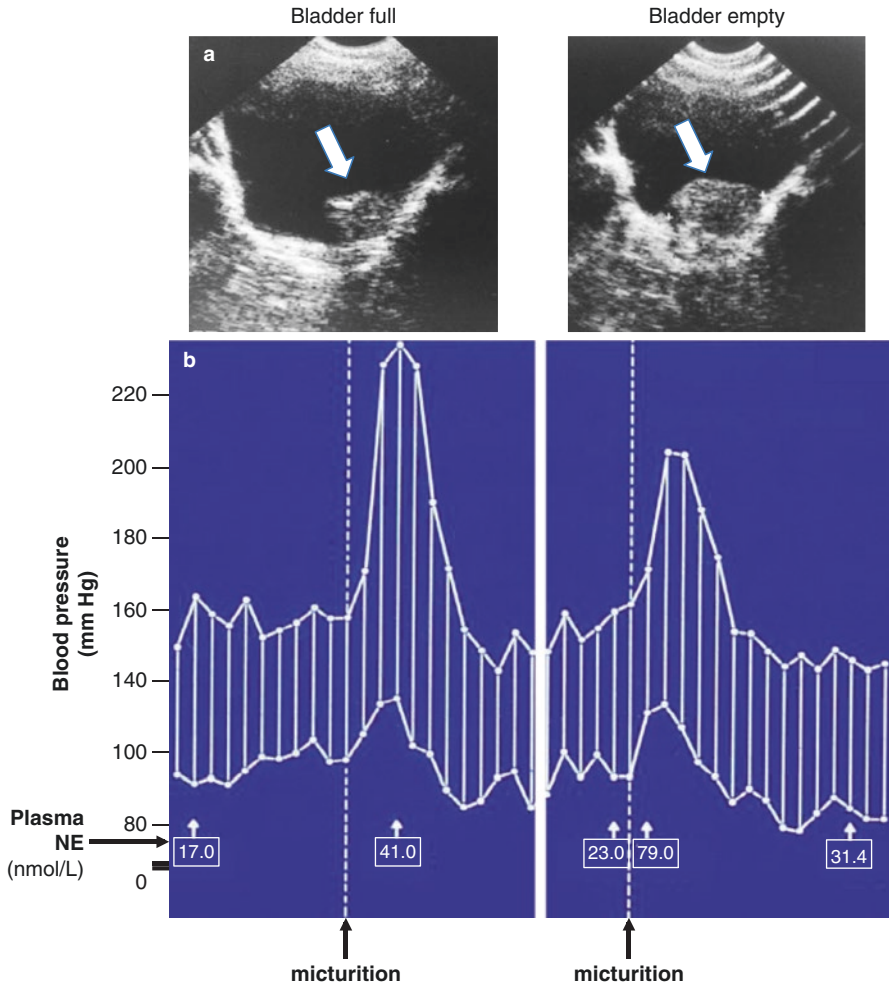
Paroxysmal hypertension in a patient with a paraganglioma of the urinary bladder. Sonograms of urinary bladder in the patient before and after micturition are shown in *panel A*. Blood pressure profiles recorded before, during, and after micturition on two separate days are shown in *panel B*. Blood samples were taken at intervals and plasma concentrations of norepinephrine (NE) measured as shown for the five time points of collections
